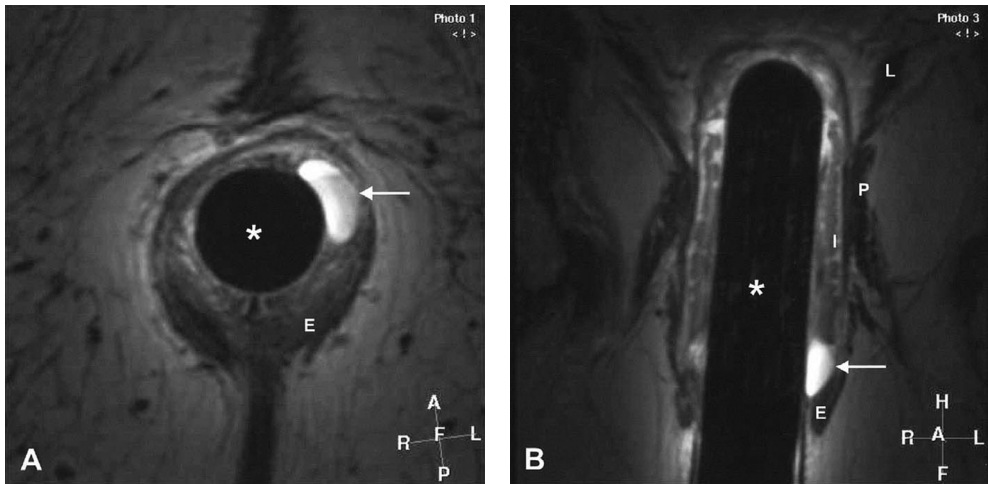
Anal sinus (pre-fistula stage). An anal sinus is a localized infection of the anal glands and crypts. (A) Axial T2-weighted fast spin-echo (FSE) endoanal MR image (TR/TE = 2000/150 ms). (B) Coronal T2-weighted FSE image (TR/TE = 2136/120 ms). A well-circumscribed lesion with high signal intensity on T2W images (arrow) can be seen submucosally. There are no additional fistula tracts. An anal sinus can heal completely or progress into a fistula. This patient had complaints of perianal pain in the last month, especially during defecation, without perianal discharge. E, external anal sphincter; I, internal anal sphincter; P, puborectalis muscle; L, levator ani muscle; Endoanal coil (*).
